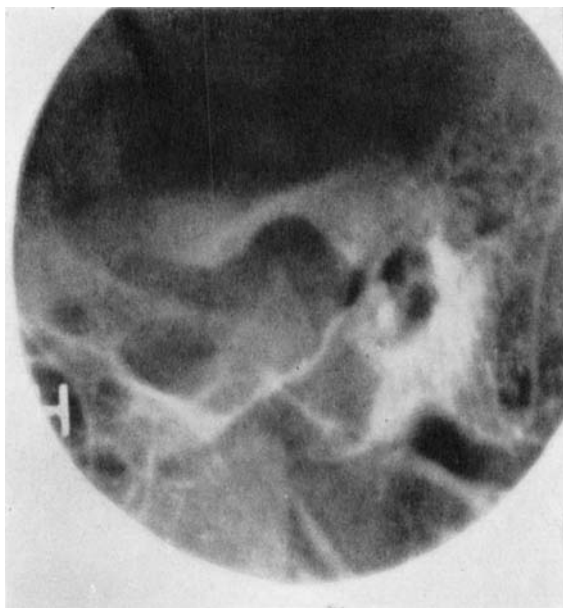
Same mandibular joint X-rayed January 25, 1950. Apart from the decalcification a considerable dislocation of the condyle, which has been pulled out of the fossa, may be seen. Furthermore, changes in the outline of the condyle are seen.
